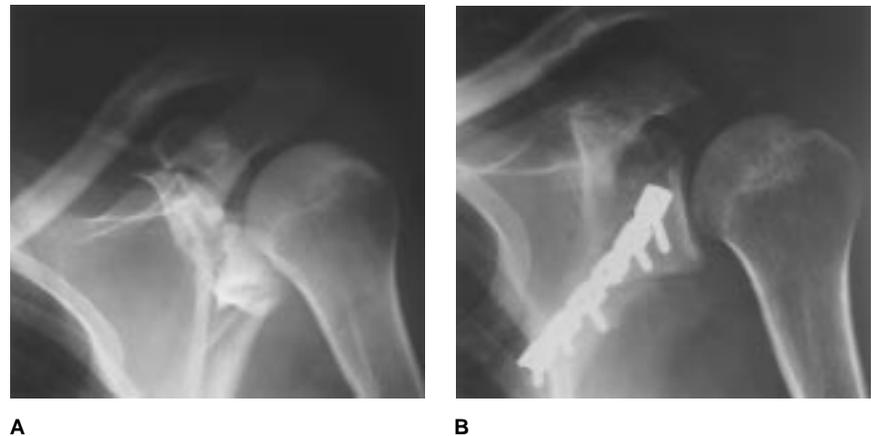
Radiographs of a patient who sustained a type II fracture of the glenoid neck. A, Preoperative AP radiograph shows significant angulatory displacement of the glenoid fragment. B, Postoperative AP radiograph shows reduction and stabilization of the glenoid fragment.
